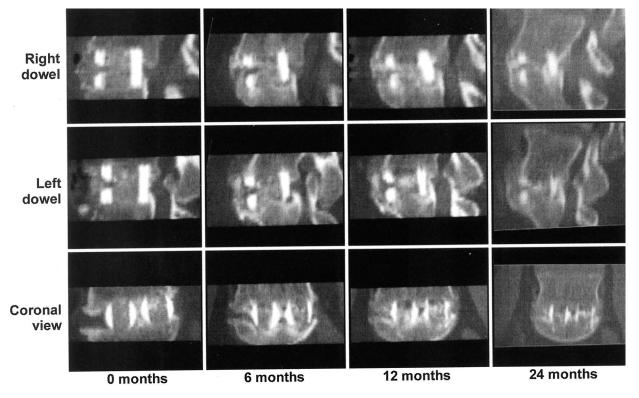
Serial thin-cut CT scans after an L5-S1 fusion using autograft demonstrate the progression of the interbody fusion. Immediate postoperative scans show corticocancellous graft within the dowels. At six months, trabecular bone connects the adjacent vertebral bodies through the dowels and anterior to the dowels. At 12 and 24 months, there is maturation of the interbody fusion with more bone formation and incorporation of the dowels into the vertebral end plates.
